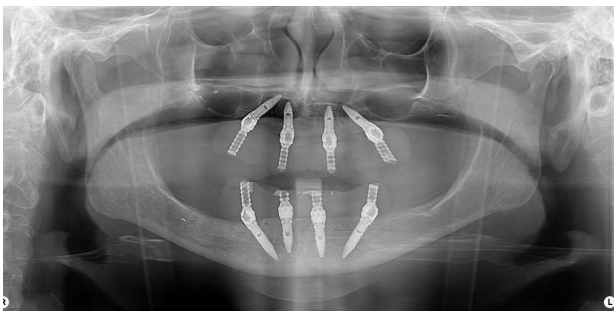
Radiographic control following implant surgery and immediate loading.*
